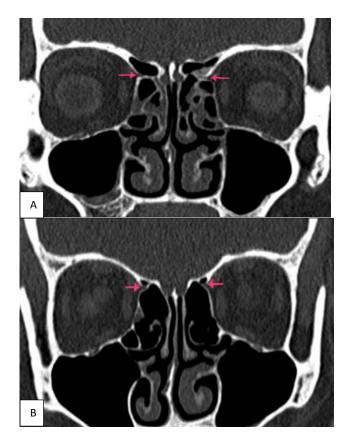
(A and B): Bony notch (arrow) depicts the anterior ethmoidal foramen. Coronal CT images in two different cases. AEA coursing freely and AEA coursing at the level of skull base.
